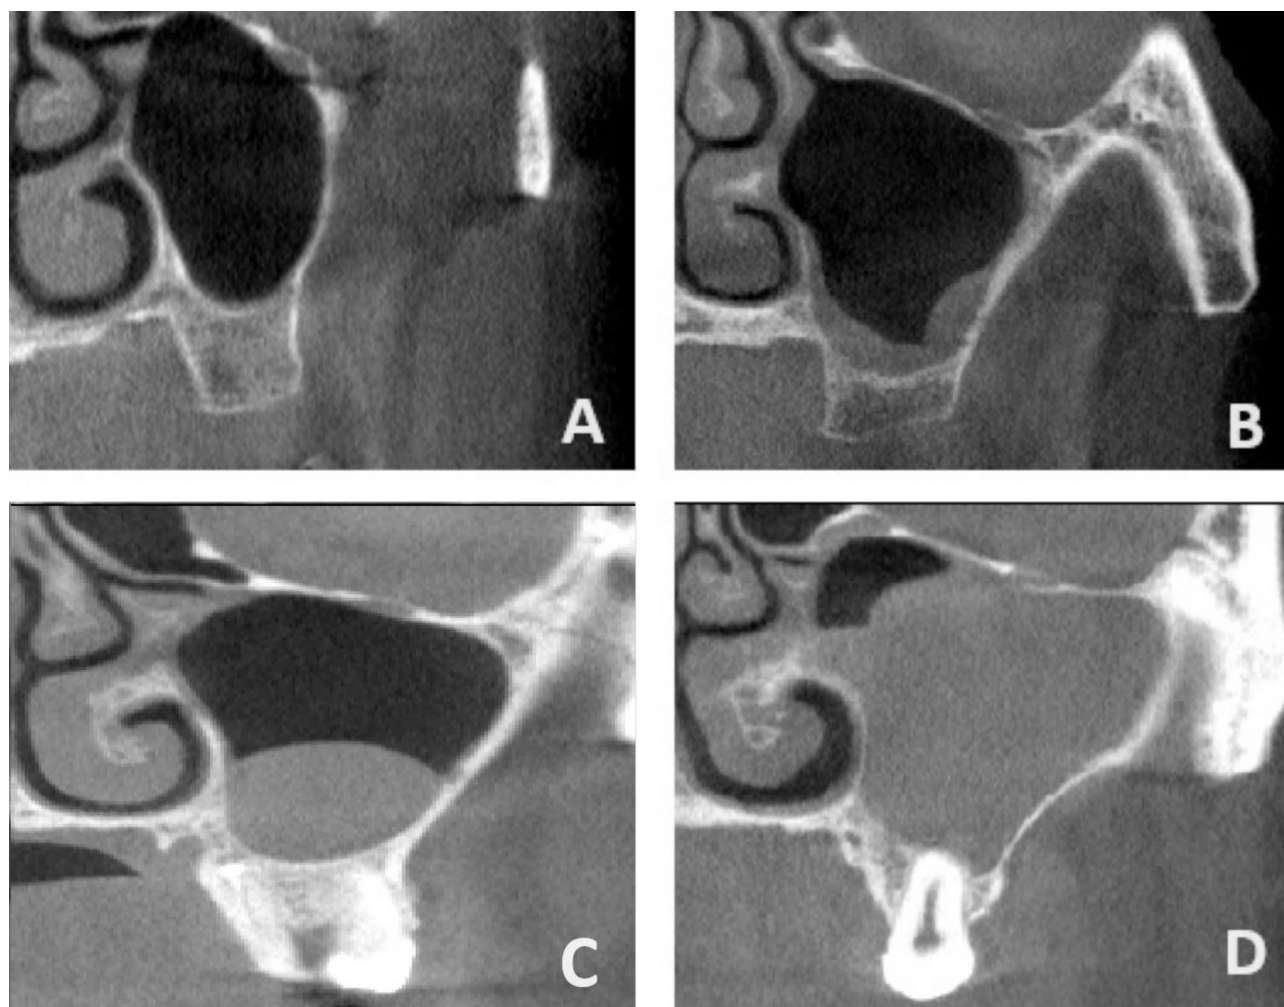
Maxillary sinus conditions identified via CBCT. (A) Clear sinus; (B) Mucosal Thickening; (C) Cyst/Polyp; (D) Opacification ($\geq 50\%$ of sinus volume)
